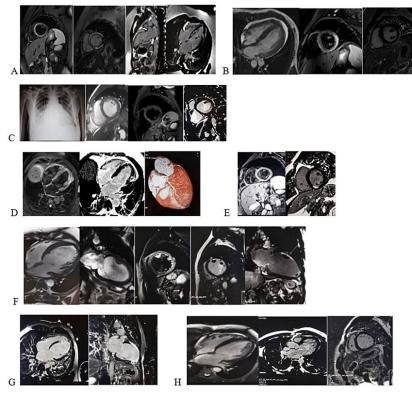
Selected Cardiac MRI cases (Cine, T2-weighted Edema, LGE images. Covid 19 Positive patients: A) Peri myocarditis: EF47% with high signal intensity in Edema images and subepicardial hyperenhancement; LGE)Pericarditis: EF 55% with edema; C) Cardiomyopathy: EF 30% with HF, Edema images with Normal LGE; D) Ischemic pattern: EF 45% with focal transmural infarction in LGE; E) Ischemic pattern: EF 45% STEMI (Transmural) in LGE; F) Ischemic pattern: EF 23% with NSTEMI (subendocardial) and LV thrombi. Covid 19 Negative patients: G) Covid 19 Negative Ischemic pattern: EF 35% with transmural infarction-ICM; H) Covid 19 Negative: EF 30% with DCM N LGE.
